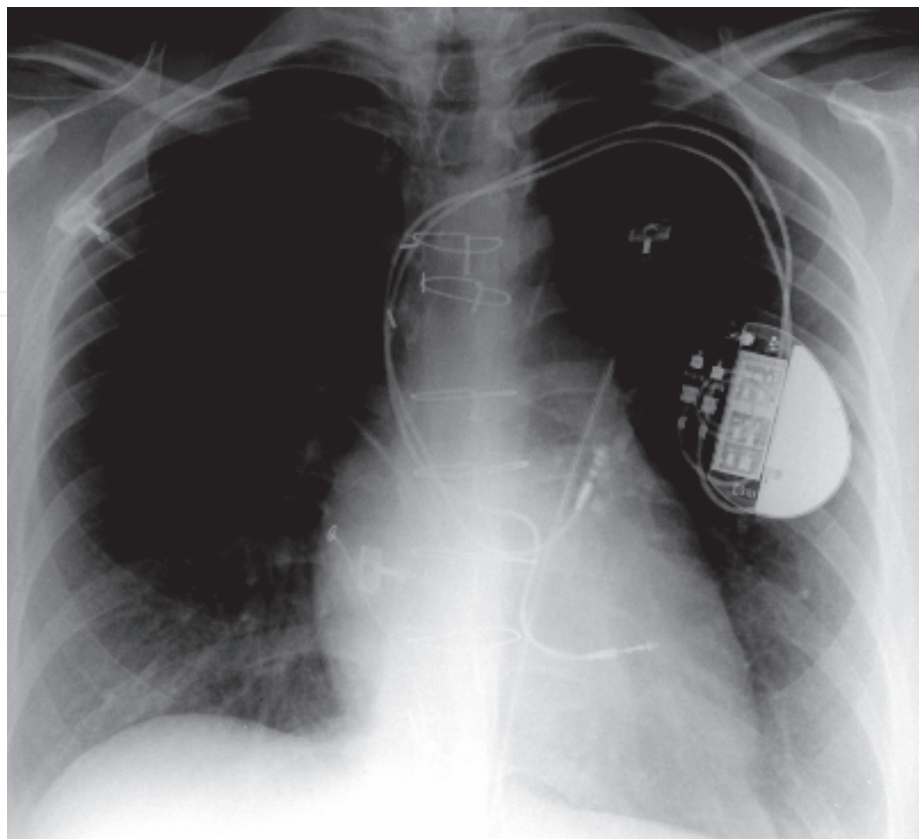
A PA chest X-ray demonstrating a ventricular lead coursing through the systemic baffle in a patient with D-Transposition of the great arteries.
